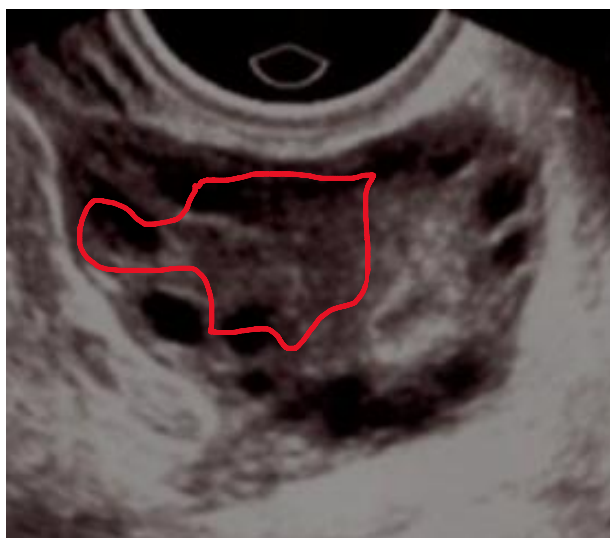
Trans-vaginal ultrasound scan showing central echogenic stroma in a case of polycystic ovary syndrome.
